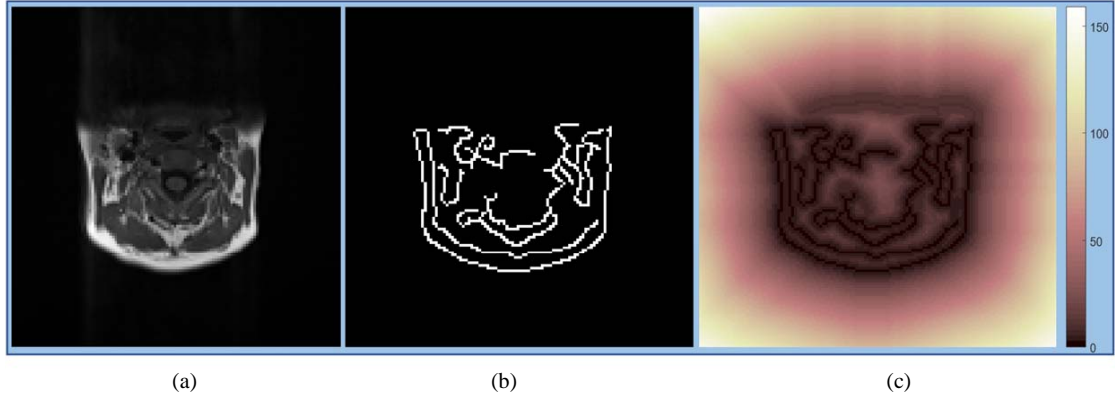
(a) Magnetic resonance imaging slice. (b) Edge image of (a). (c) Chamfer distance image of (b). The binary and Chamfer distance images are calculated for a 3D image but the results are shown in 2D.
